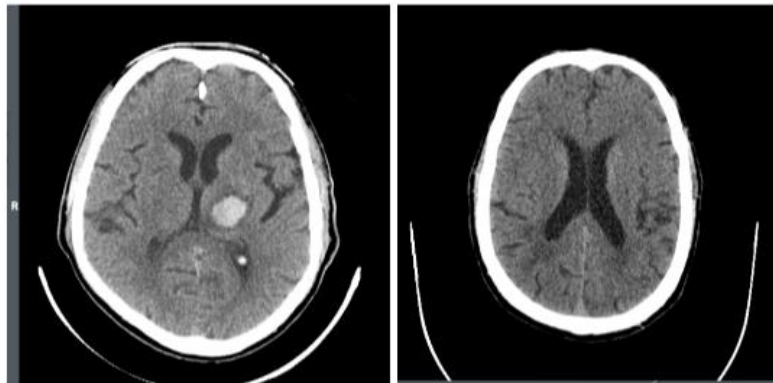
CT slices with the presence of hemorrhage and no presence after preprocessing stage [29]
